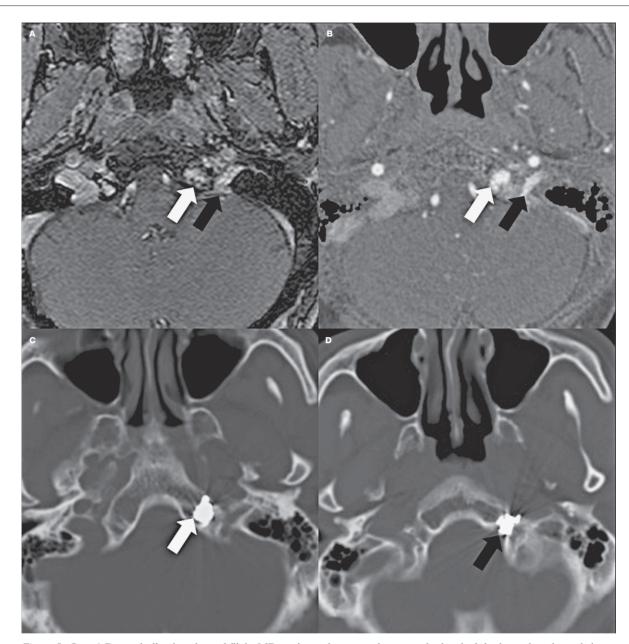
Case 6. Pre-embolization time of flight MR angiography source image at the level of the hypoglossal canal shows high flow inside the left hypoglossal canal (black arrow) and adjacent basiocciput (white arrow). It is also well depicted on the CT angiography source image (B). Post-embolization CT angiography shows a coil mass inside the basiocciput (C, white arrow) and hypoglossal canal (D, black arrow).
